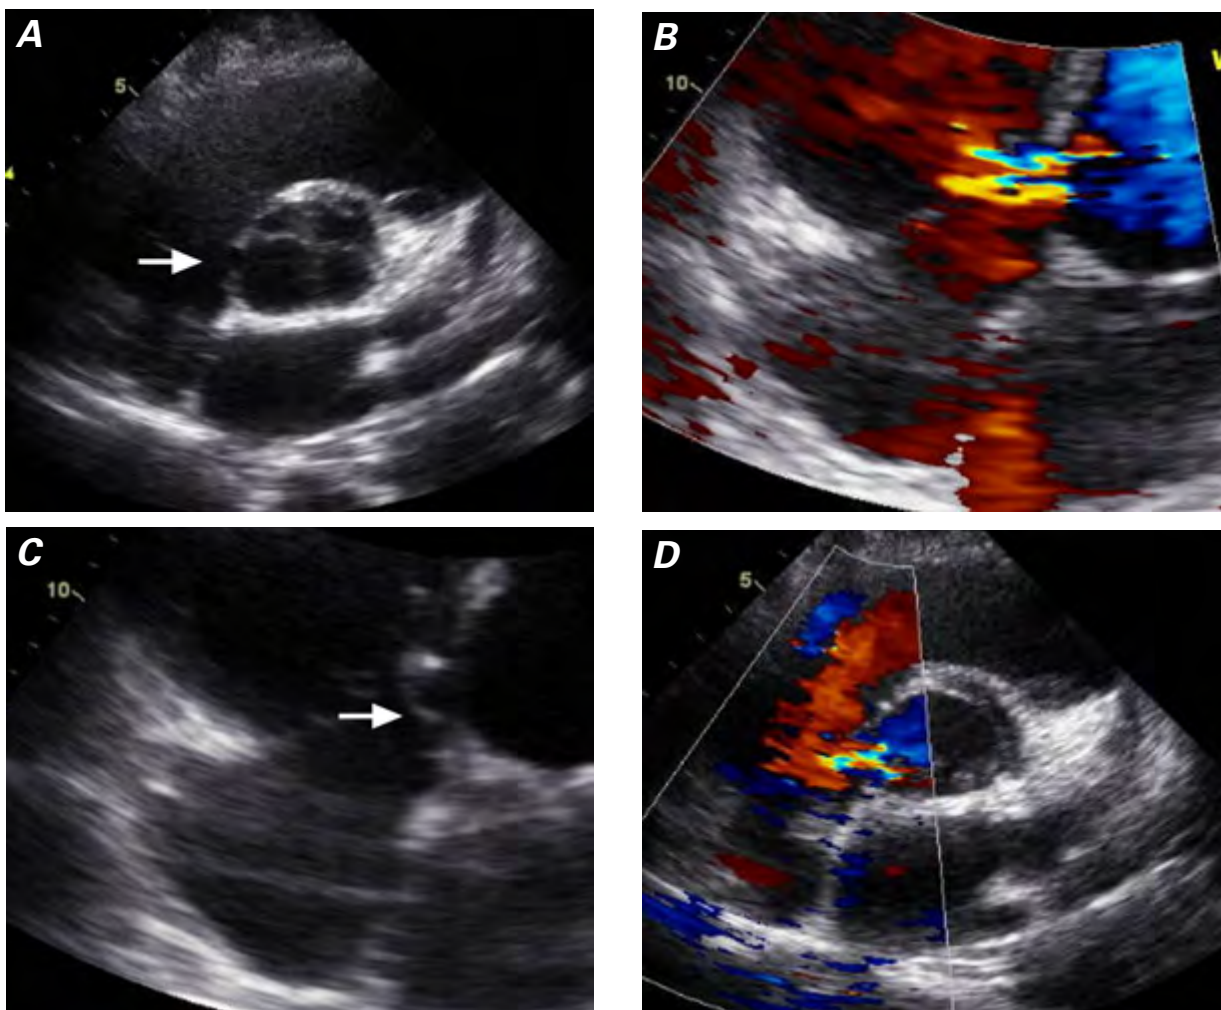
Two-dimensional echocardiograms (parasternal short-axis view) show A) the Gerbode defect (arrow) and B) the shunt flow (color-flow Doppler mode). Two-dimensional echocardiograms (modified apical 4-chamber view) show C) the Gerbode defect (arrow) and D) the shunt flow (color-flow Doppler mode).
